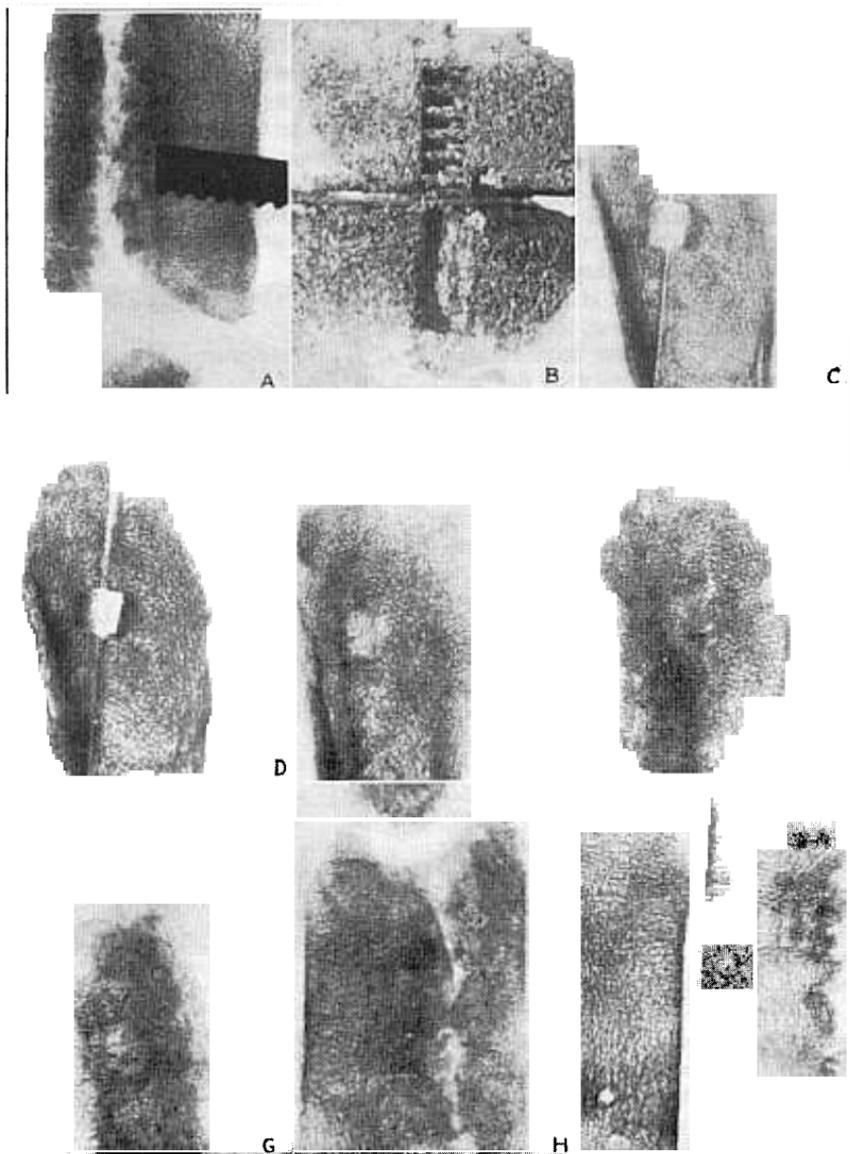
Chamber in bone at different angles: *A*, as made by a metal bar, producing a chamber one-fourth by one-fourth by one-half inch; *B*, appearance of chambers in separated bones; *C*, appearance with rays in line with the long axis of the chamber; *D* (10 degrees), *E* (20 degrees), *F* (30 degrees), *G* (60 degrees), and *H* (90 degrees) at different angles; *I* (90 degrees), the two pieces separated and roentgenographed at right angles to the long axis of the chamber. The bent wires indicate the angles. There is practically complete disappearance of this large chamber.
